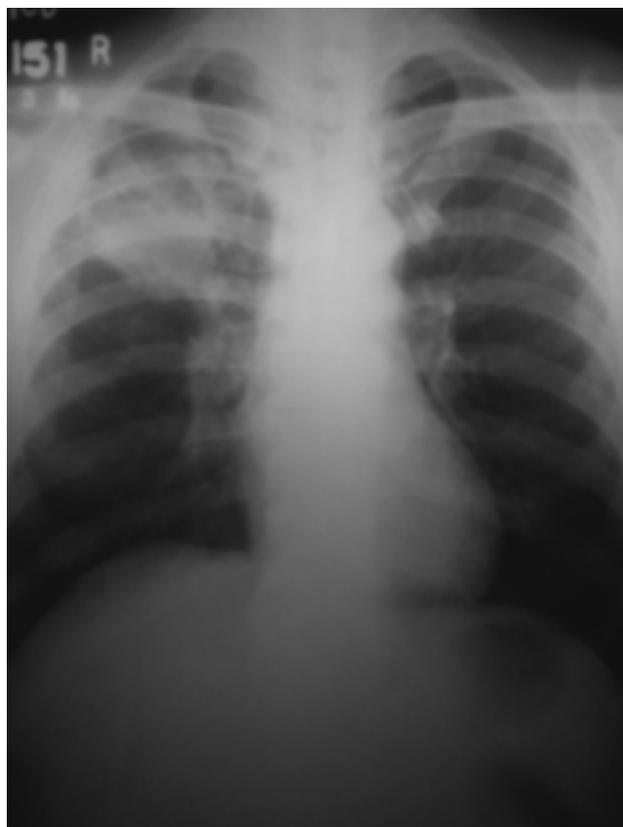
Repeat Chest X-ray showing increasing opacity
